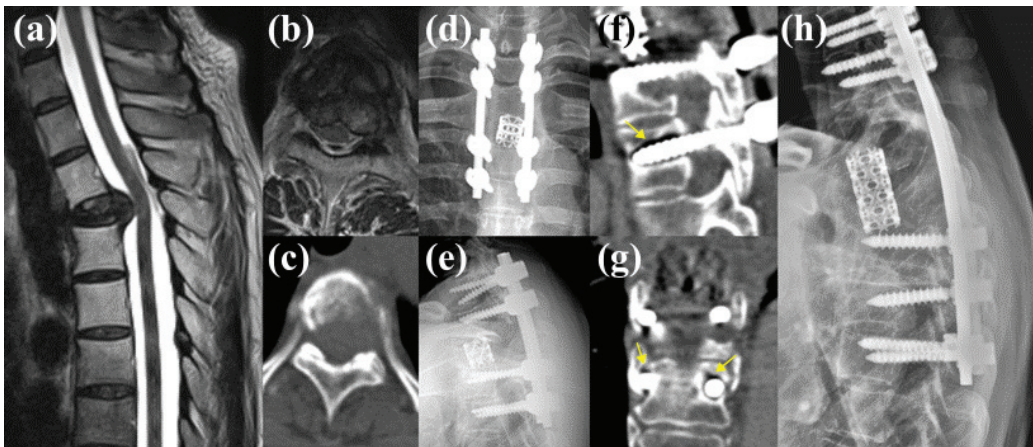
Case involving a 48-year-old female patient with renal cell carcinoma metastasis to the T4 vertebra. (a–c) Preoperative magnetic resonance imaging and computed tomography (CT) imaging revealed the metastatic lesion. (d,e) The patient underwent a T4 spondylectomy with mesh cage insertion and posterior fixation from T2 to T6. Preoperative computed tomography (CT) imaging showed an average Hounsfield unit value of 264.862 at the upper instrumented vertebra and 103.201 at the lowest instrumented vertebra. (f,g) Approximately 17 months postoperatively, the patient experienced aggravated back pain, and CT imaging revealed loosening of the bilateral pedicle screws at the T6 vertebra (yellow arrows), (h) leading to revision surgery extending the fixation from C7 to T7.
